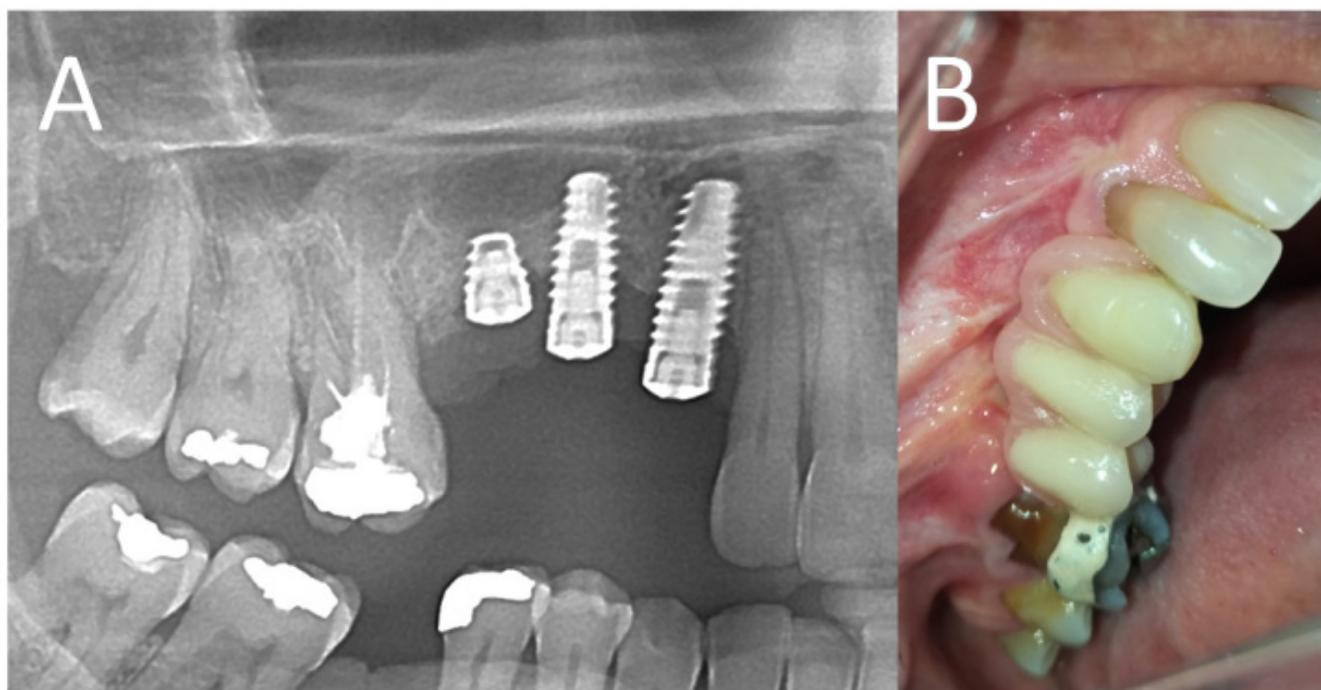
Post-surgical control radiograph. Image suggestive of implant osseointegration (A) and adhesive temporization with metallic infrastructure and acrylic resin, in order to avoid premature overload on the implants.
